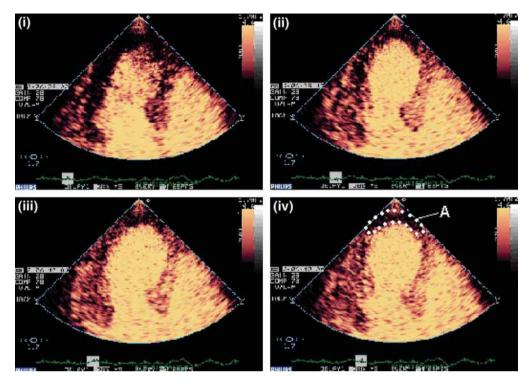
Frame (i) is immediately following a high power ultrasound flash that destroys the microbubbles within the myocardium. Frames (ii) to (iv) show replenishment of microbubbles in the septum and lateral walls within two heartbeats. A clear apical perfusion defect (A) that persists is demonstrated. (Reproduced with permission from R Janardhanan, et al. Myocardial contrast echocardiography: a new tool for assessment of myocardial perfusion. Ind Heart J 2005;57:210–216.)
